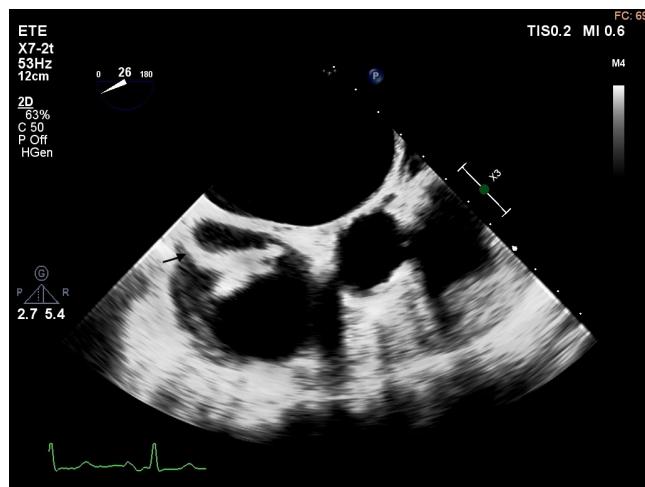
Calcified tip of a central venous catheter adhering to the right atrium and superior vena cava entrance, in a transoesophageal echocardiogram.
